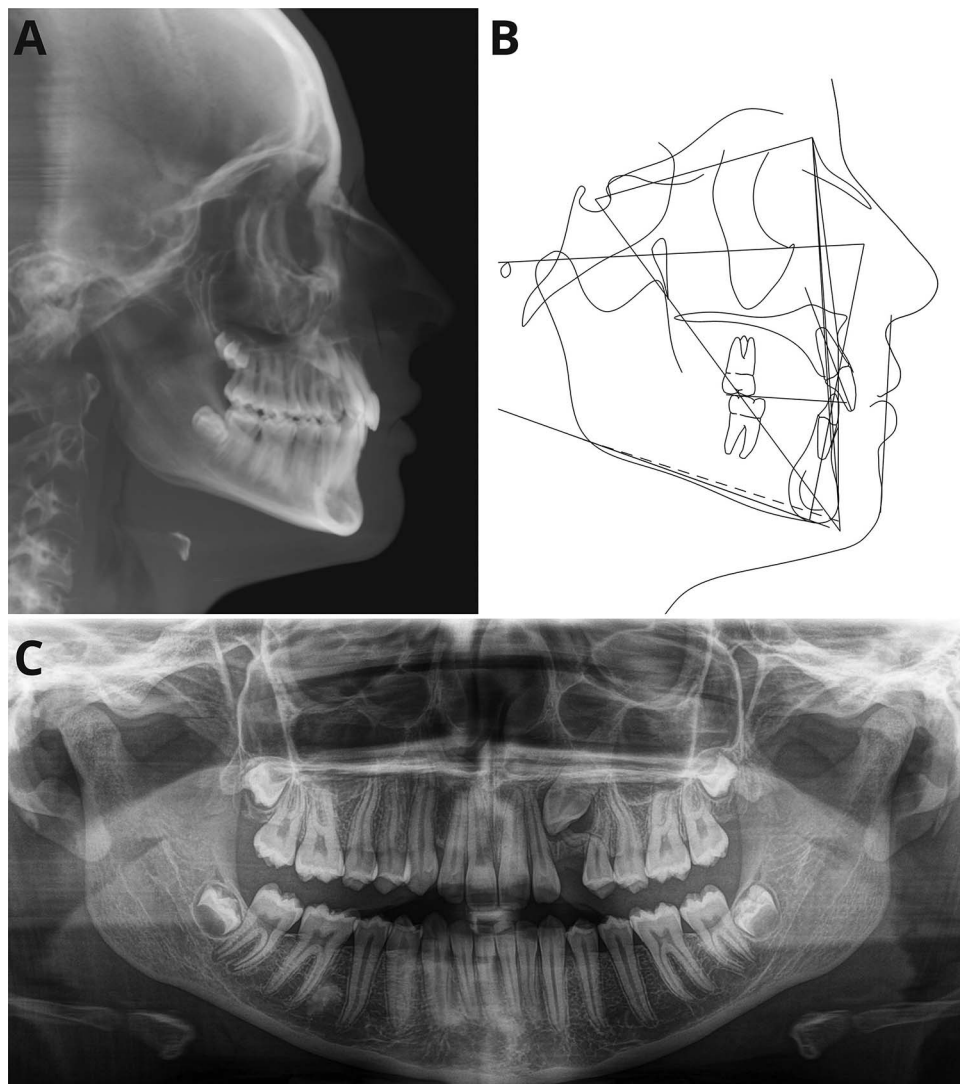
Pretreatment radiographs: (A) Lateral cephalogram; (B) Cephalometric tracing; (C) Panoramic radiograph.
